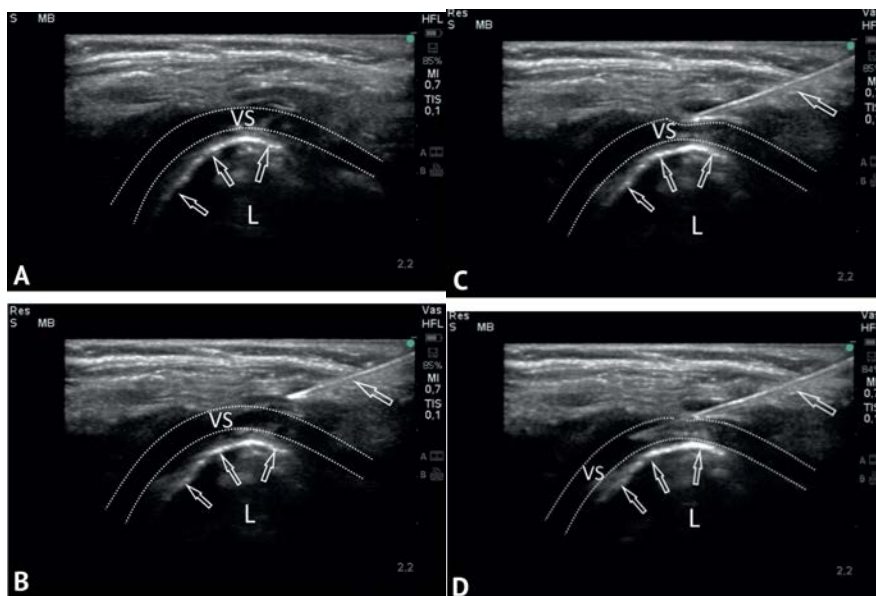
The supraclavicular technique to puncture the subclavian vein using ultrasound navigation: A — general view during ultrasound scanning from the supraclavicular region: VS — subclavian vein, L — lung, arrows indicate the parietal pleura; B — an 18-gauge needle is inserted through the skin into the soft tissues, the needle is marked with an arrow; C — the moment of a puncture of the vein's wall; D — intravascular needle tip position
